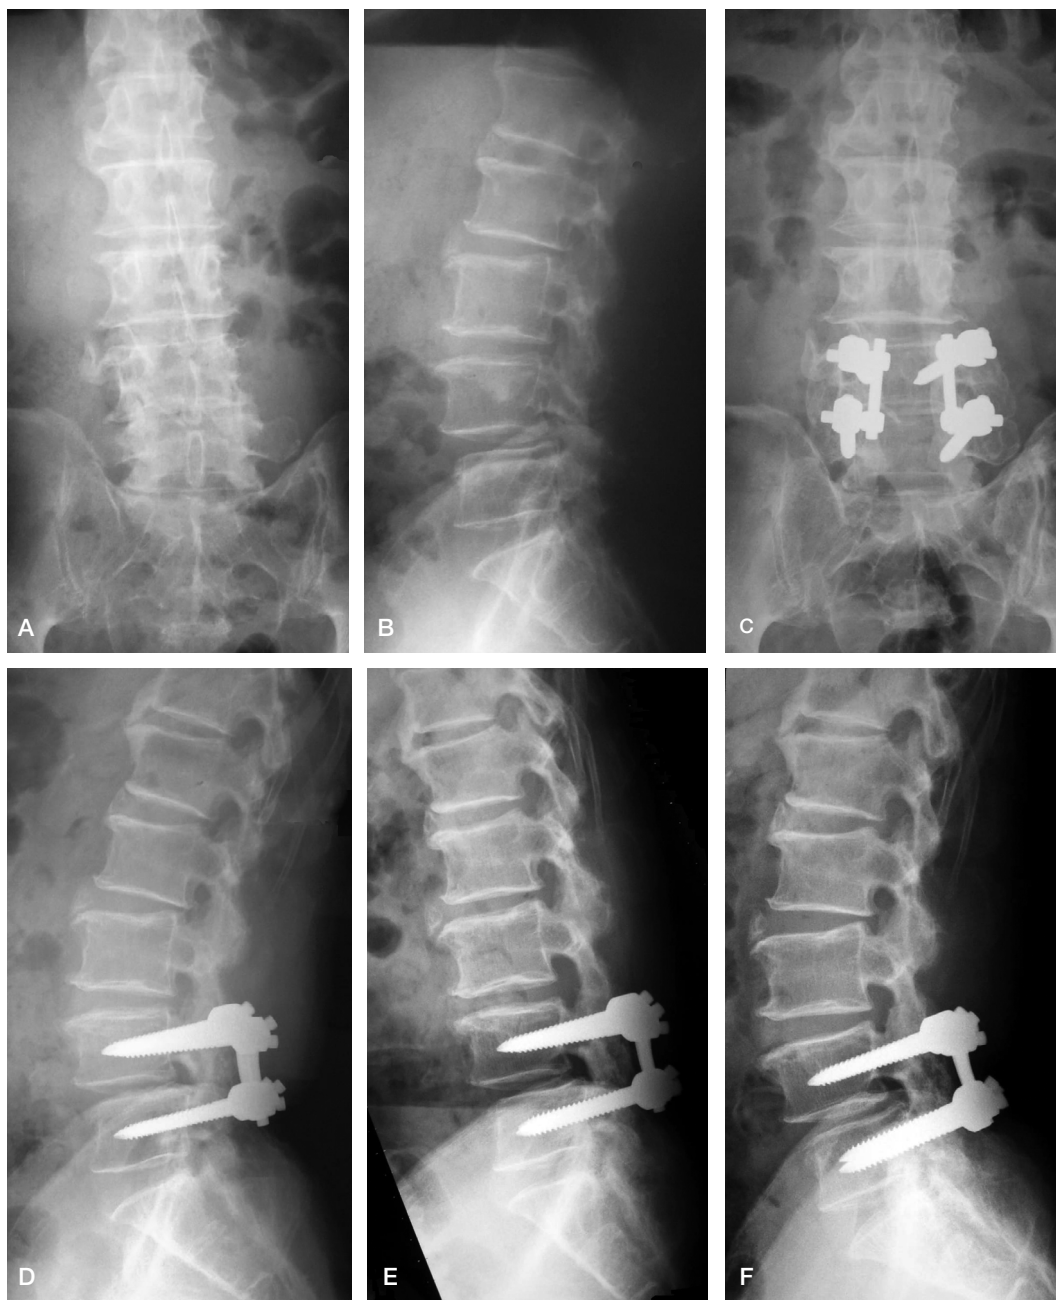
A 67-year-old man. Preoperatively, anteroposterior (A) and lateral (B) views showing degenerative spondylolisthesis at L4/L5. Two years postoperatively, anteroposterior (C), lateral (D), flexion (E) and extension (F) views showed stable implants, solid fusion, and no motion in flexion and extension on stress radiographs.
